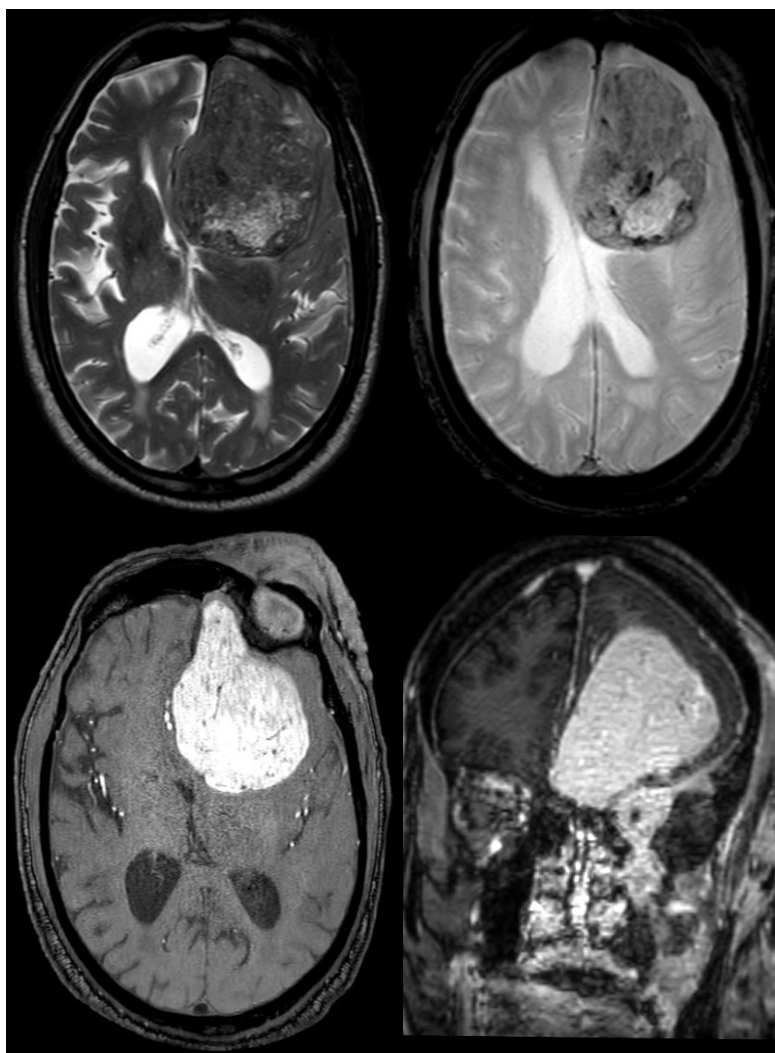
MRI complement was performed, on axial T2, and T2*, axial and coronal T1 with gadolinium demonstrating that this tumor is isointense to grey matter , containing multiple flow voids seen on T2* with vivid and heterogenous enhancement and extension to the left orbit
